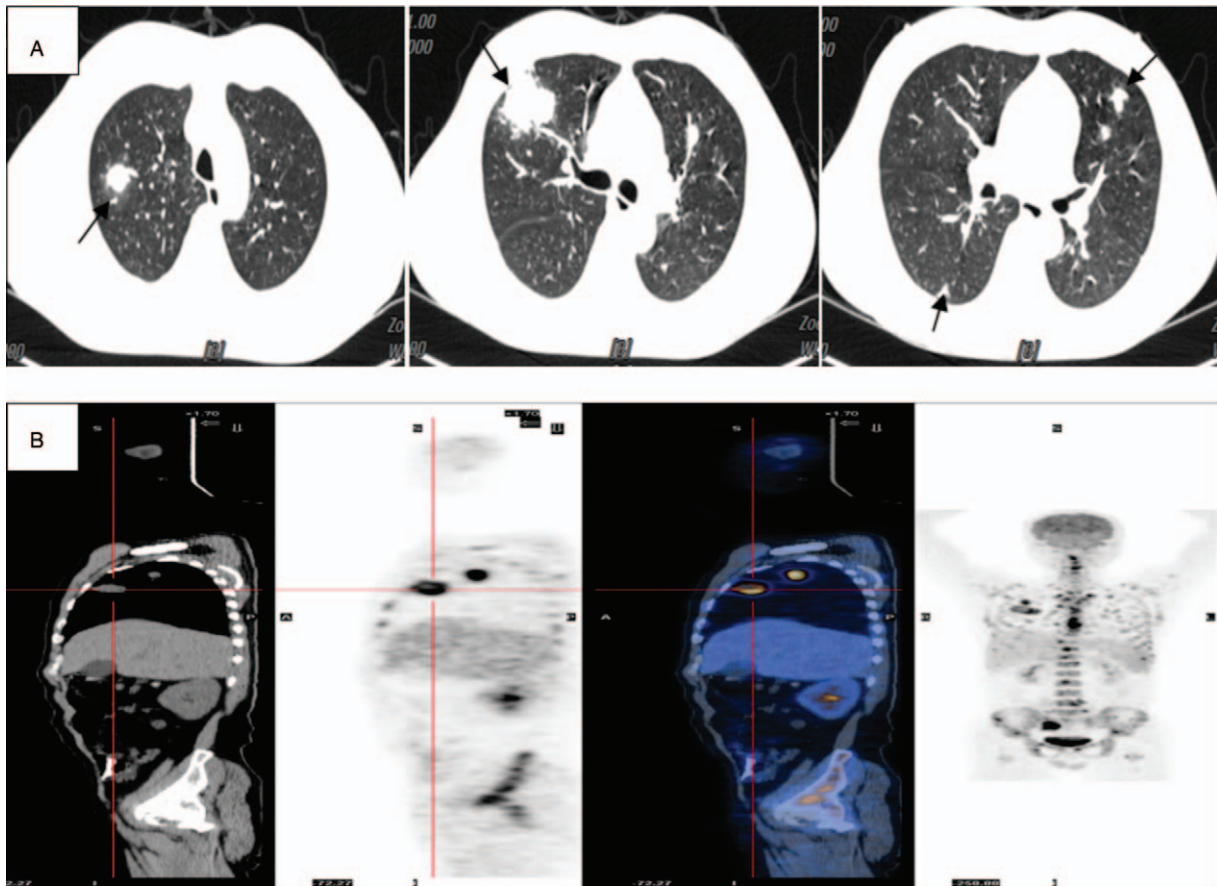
Chest CT scan showing multiple nodes in both lungs. (B) PET imaging revealing lobulated heterogeneous hypermetabolic masses in both lungs, as well as in the pelvic cavity, spleen, and bones. Additionally, multiple lymph node metastases involving the mediastinum and right hilum can be identified.
